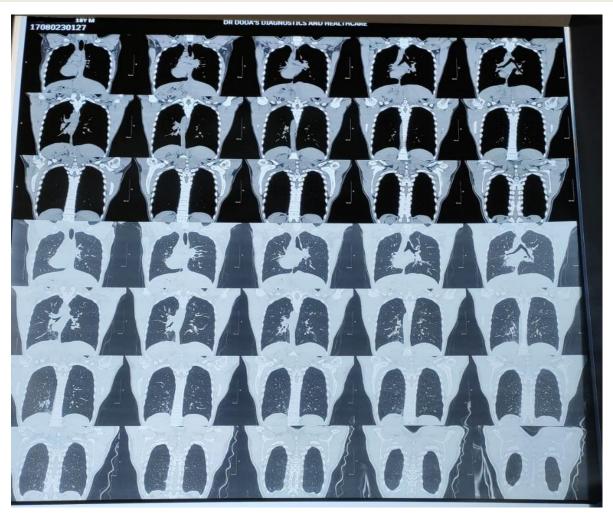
HRCT chest showing bronchiectatic changes in the both lungs fields and bilateral ground glass opacities
